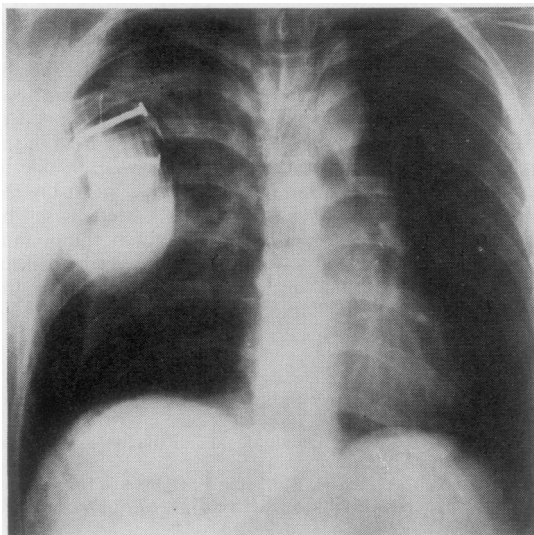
PA chest radiograph at the time of the patient's hospital admission. Note partial collapse of the lung, absence of haemothorax, and prominent nails in the intrathoracic pole.
